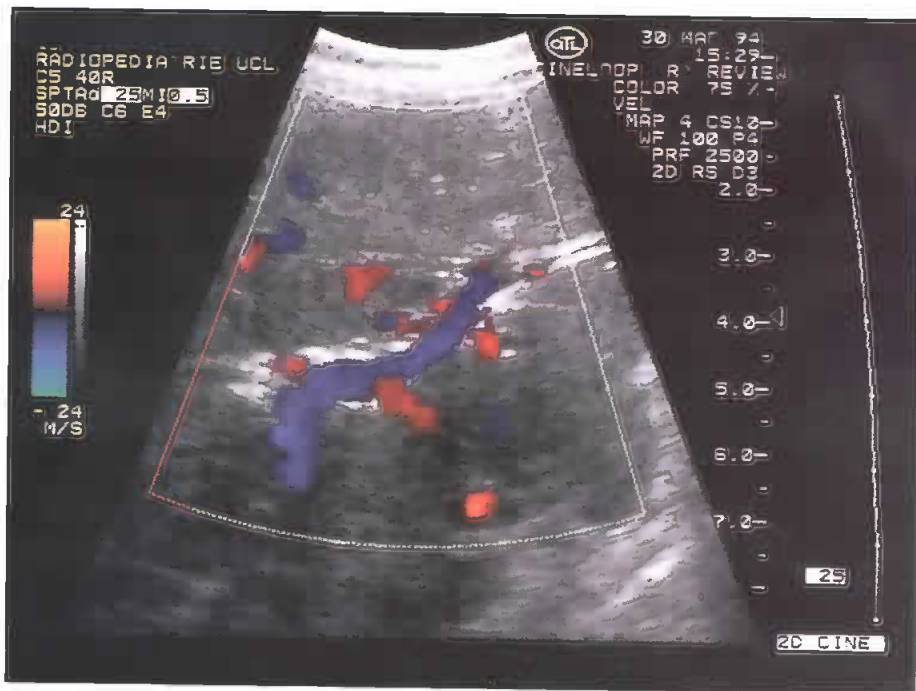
Doppler ultrasound in a child transplanted with a full-size liver graft and presenting with portal trunk thrombosis. The intrahepatic portal system is not thrombosed. The blue stream corresponds to the portal flow (from right to left: from the Rex recessus to the right portal vein). In the left portal branches there is an inversed flow which enters the right liver.
